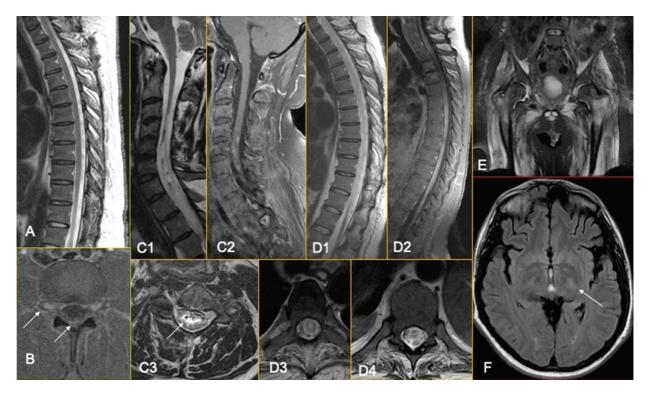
Initial dorsal MRI (A) was normal, and a significant contrast enhancement was observed in the axial T1 fat-sat image of the lumbar spine, involving the dorsal ganglia and the lumbo-sacral plexus inside the spine canal (B). After 3 months of evolution, the patient developed longitudinal extensive transverse myelitis (C, D), already with focal tapering of the cervical/dorsal transition on sagittal STIR (C1), remembering a sequel area. The lesion was centrally located (C3, D3), with anterior horn involvement (D4) and signals of previous bleeding inside the central canal (C3). A patch and irregular contrast enhancement were noticed along the sequel area (C2) and along the entire dorsal spinal cord (D2). Consequent muscle denervation was observed in the coronal STIR of the pelvic girdle muscles (E) and ascendant cortical-spinal tract degeneration consequent to the spinal cord damage on FLAIR axial images (F).
